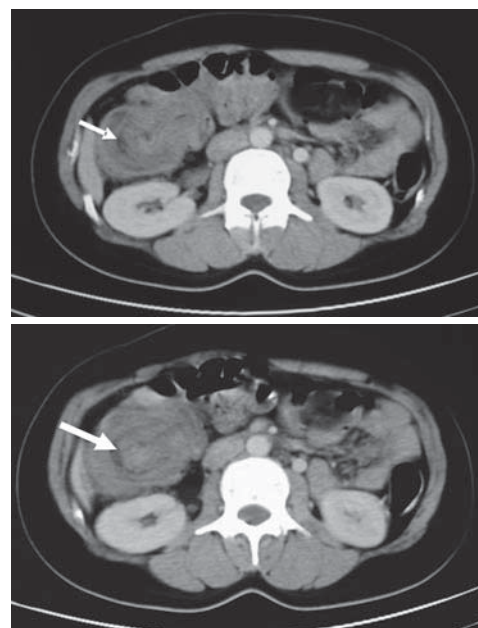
Computed tomography of the abdomen showed a coil spring appearance mass (arrow) about 7cm in diameter at ascending colon.
